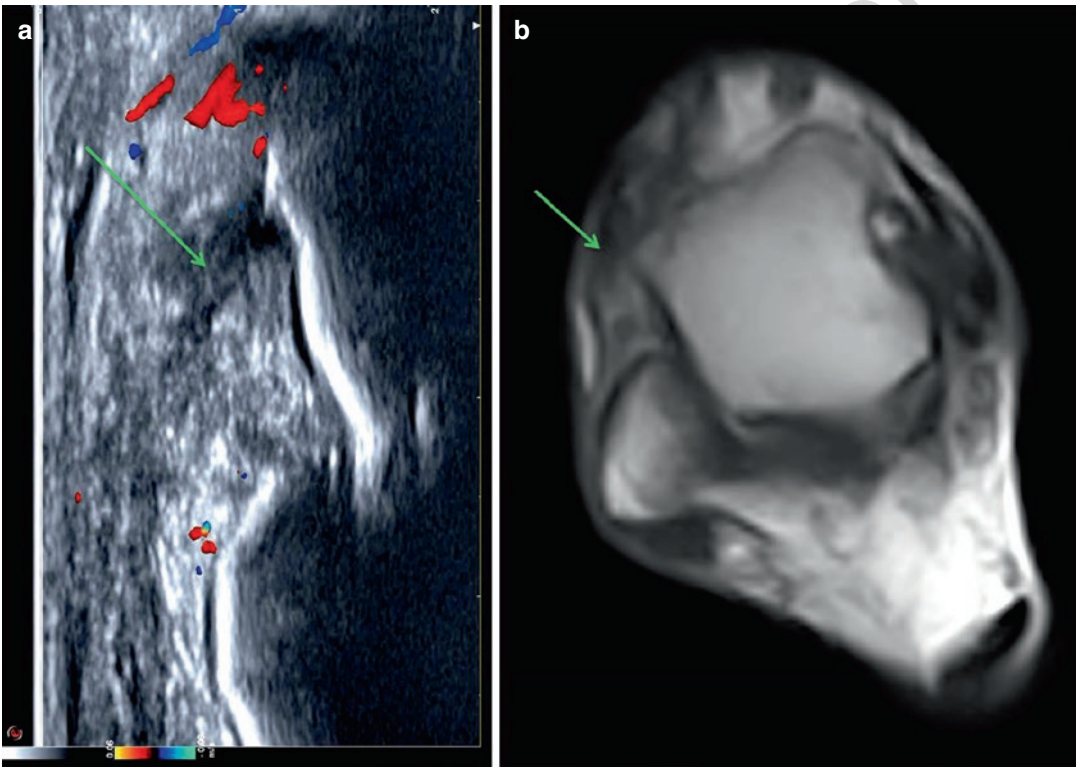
(a, b) Dynamic US and MRI scans acquired with the ankle inverted demonstrating a full-thickness lesion of the anterior talofibular ligament
